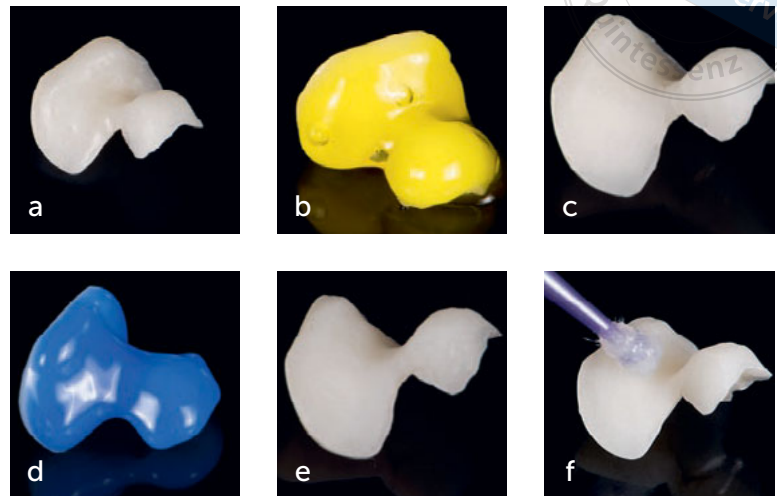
(a) Surface of the PGCR prior to surface conditioning. (b) 9% hydrofluoric acid etching. (c) Surface of the restoration after hydrofluoric acid etching. (d) Cleaning the restoration using 37% phosphoric acid. (e) Surface after 5 min in an ultrasonic bath with demineralized water. (f) Application of silane.
